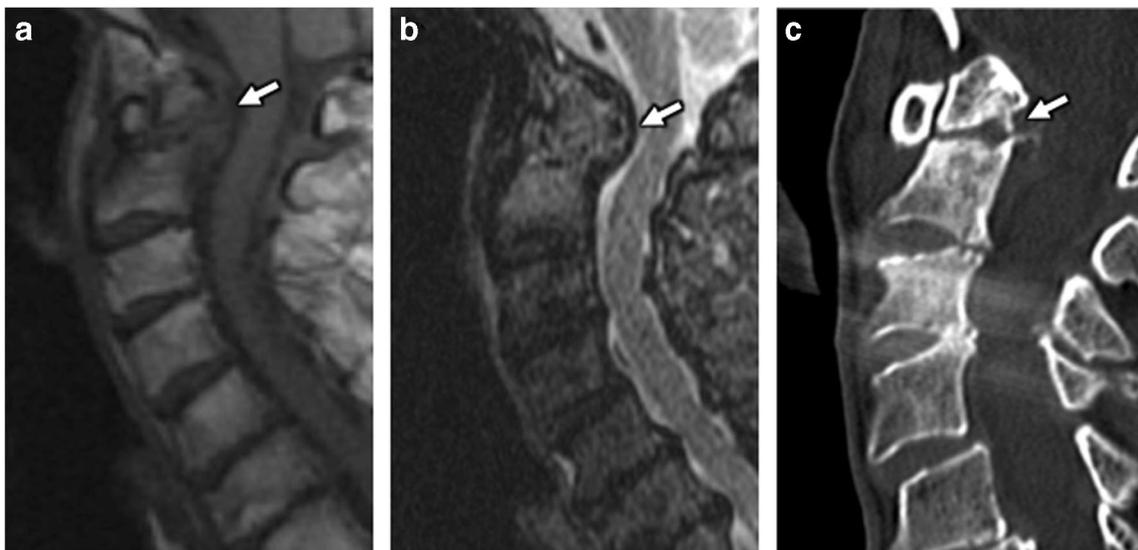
a An 82-year-old woman with history of chronic dens fracture and soft tissue proliferation about the dens. Sagittal T1-weighted image demonstrates T1 hypointense soft tissue (*arrow*) posterior to the dens. b Sagittal T2-weighted image demonstrates heterogeneously T2
